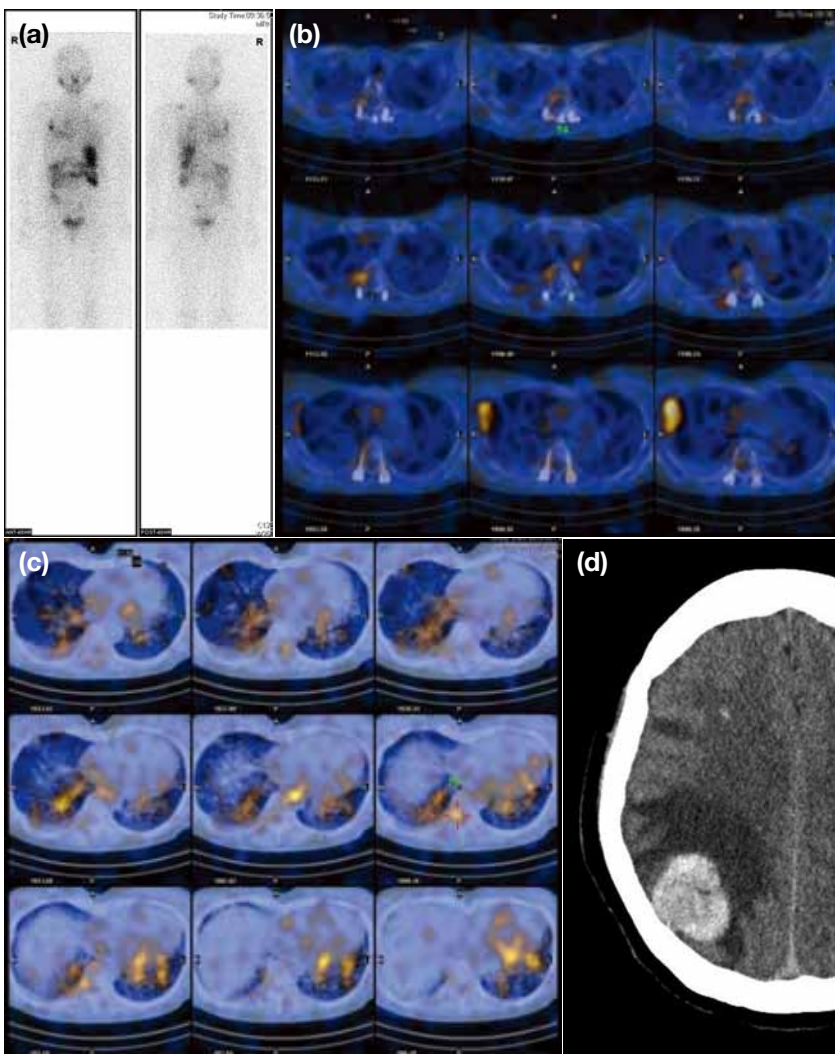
(a) Biplanar whole-body scans show no evidence of local recurrence, and suspicious uptake in the left shoulder and right side of the head, with equivocal uptake in the right hemithorax and thoracic spine. (b) and (c) SPECT/CT images show lytic metastasis in the right fourth rib with T4 vertebral metastasis, disseminated lung metastasis, and T9 vertebral metastasis, respectively. (d) Non-contrast CT image of the brain shows hyperdense metastases to both cerebral hemispheres, with the largest lesion in the right parietal lobe.
